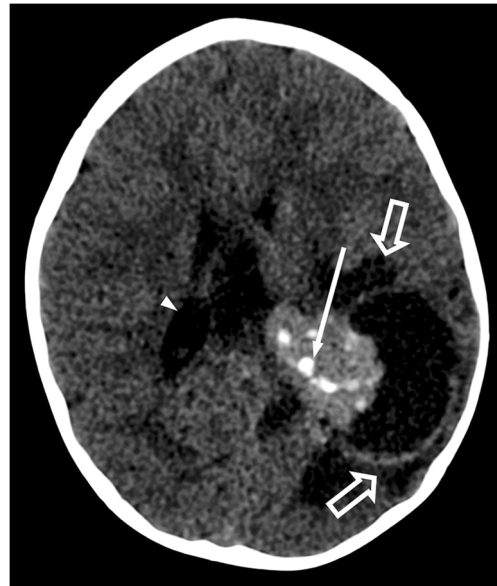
Choroid plexus carcinoma in a 2-year-old girl. Nonenhanced CT axial image shows a fairly large and dense mass in the atria of the left lateral ventricle with punctate and coarse calcification (*thin arrow*), ventricular entrapment and mild hydrocephalus (*arrowhead*). In addition, note the vasogenic edema in the left parietal region with parenchymal invasion (*thick arrows*)
